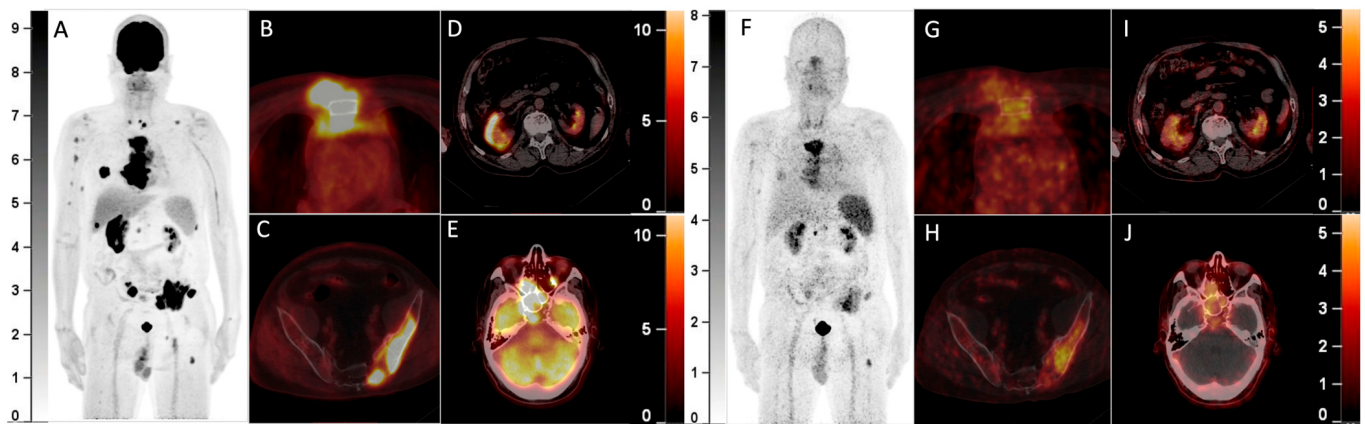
A 64-year-old man with a history of multiple myeloma (MM) for 8 years, recently presented with a parasternal mass and blindness of the right eye. Serum protein electrophoresis and immunofixation electrophoresis showed positivity for the monoclonal protein (16.2 g/L, IgA- λ). A biopsy of the parasternal mass confirmed plasmacytoma. Considering the recurrence of MM, ^{18}F -FDG PET/CT was referred. The maximum intensity projection (MIP) of the PET (A) detected multi-foci with intense radioactivity all over the body. The axial fusion images (B,C, bone window) showed most of the FDG-avid foci were located in bone marrow, most prominently in the sternum and pelvis (SUVmax 34.0), accompanied by lytic bone destruction and paramedullary masses. Additionally, the axial fusion images (D,E, soft tissue window) demonstrated extramedullary disease (EMD) with intense FDG uptake in the right kidney and paranasal sinus (SUVmax 22.3), which also involved the right orbit and temporal lobe. Since ^{68}Ga -Pentixafor has been reported to be advantageous over ^{18}F -FDG in assessing MM^{1,2}, he was included in the clinical trial of ^{68}Ga -Pentixafor (NCT03436342). In the MIP (F) and corresponding axial fusion images of ^{68}Ga -Pentixafor PET (G–J), the above hypermetabolic foci showed significantly lower tracer uptake as compared with ^{18}F -FDG PET (bone marrow lesions: SUVmax 16.5; EMD: SUVmax 7.4).
